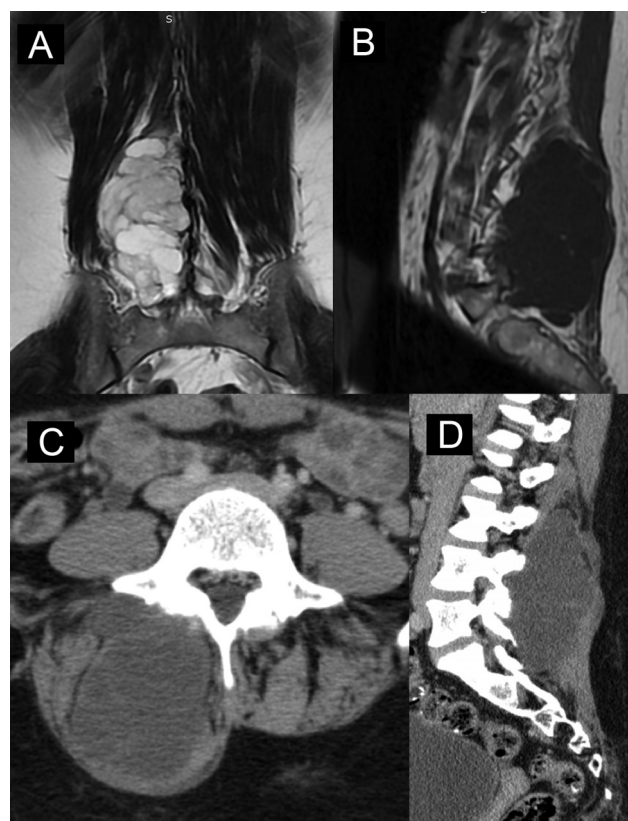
Lumbosacral spine: (A) T2-weighted MRI coronal view with hyperintense multilobulated paraspinal tumor. (B) sagittal view shows hypointense tumor on T1-weighted MRI. (C) axial and (D) sagittal CT scans demonstrate a low-density mass, with remodeling of adjacent bony structures.
